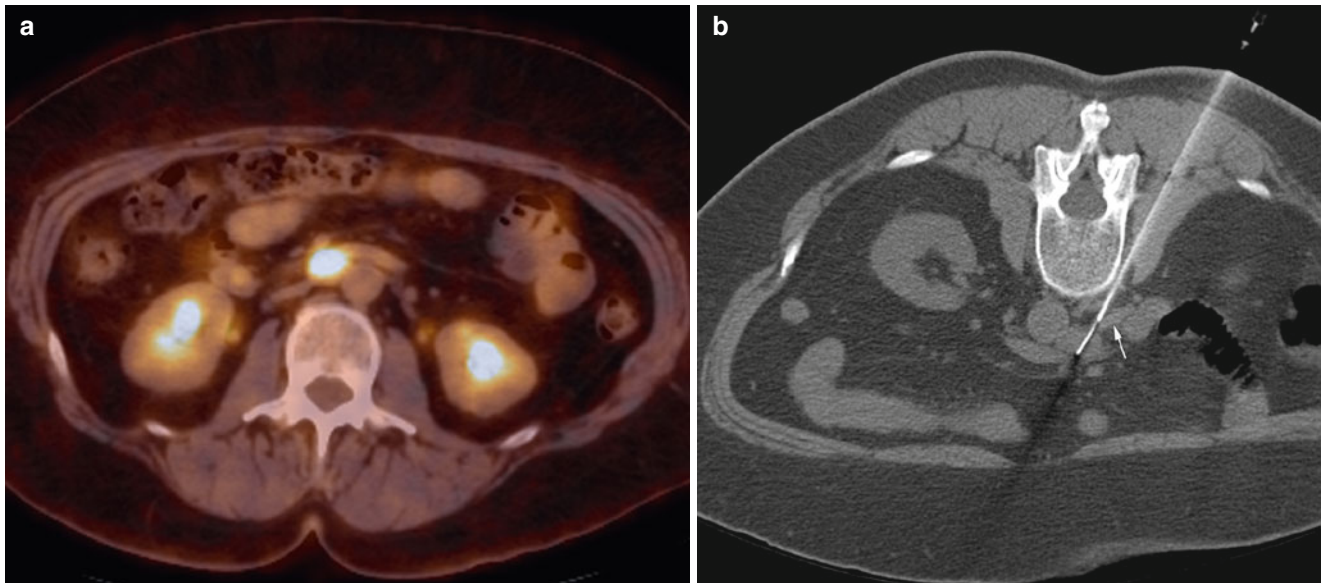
A 56-year-old woman with history of ovarian cancer underwent PET/CT for restaging. Axial PET/CT image of the abdomen (a) shows a mass with high metabolic activity in aortocaval space. Axial
